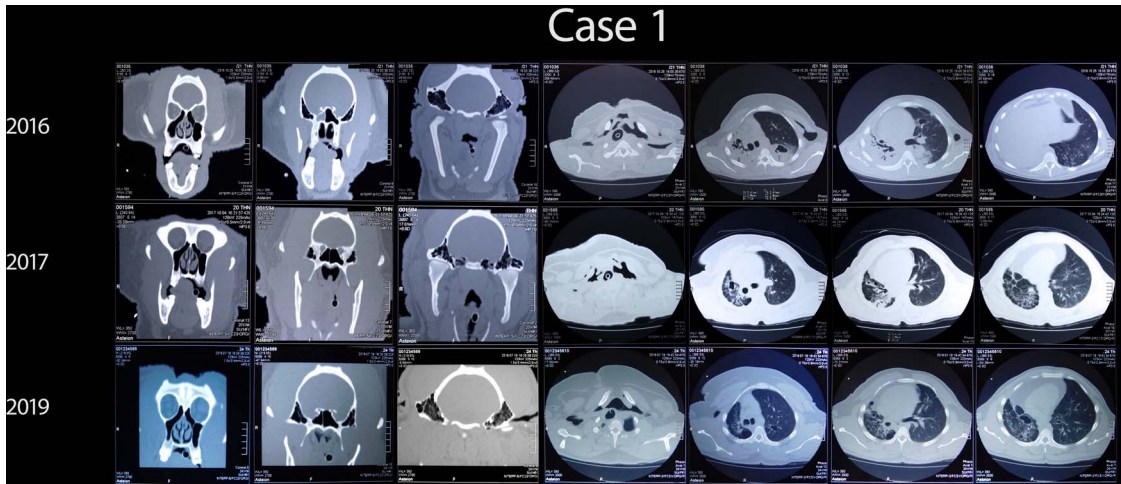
Serial CT Scan images of head, neck, and thorax of Case 1 from 2016 to 2019. The first CT scan in 2016 (top row) showed the baseline condition before the start of ORDS long-term treatment. The right lung was so severely consolidated that it was not visible. The second CT scan in 2017 (middle row), taken after 3 months of long-term treatment, showed a dramatic improvement of the right lung. Bronchiectasis was well observed in both lungs. The third CT scan in 2019 (bottom row), taken after 24 months of long-term treatment, showed that the right lung was relatively unchanged since the previous scan, while there were some improvements on the consolidated area in the left lung.
